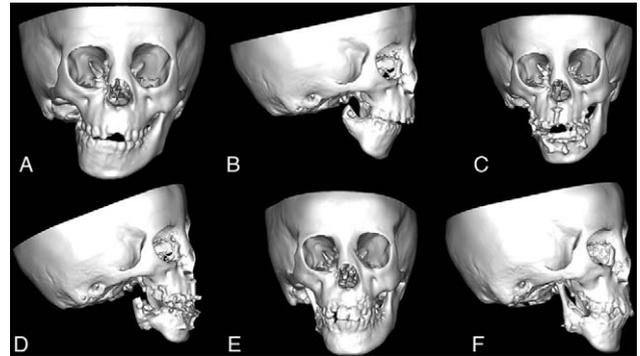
Preoperative three-dimensional computed tomographic scan at age of 3.8 years: (A) anteroposterior view and (B) right lateral view. Postoperative (1 wk) three-dimensional computed tomographic scan: (C) anteroposterior view and (D) right lateral view. Postoperative three-dimensional computed tomographic scan at age of 9 years: (E) anteroposterior view and (F) right lateral view.
